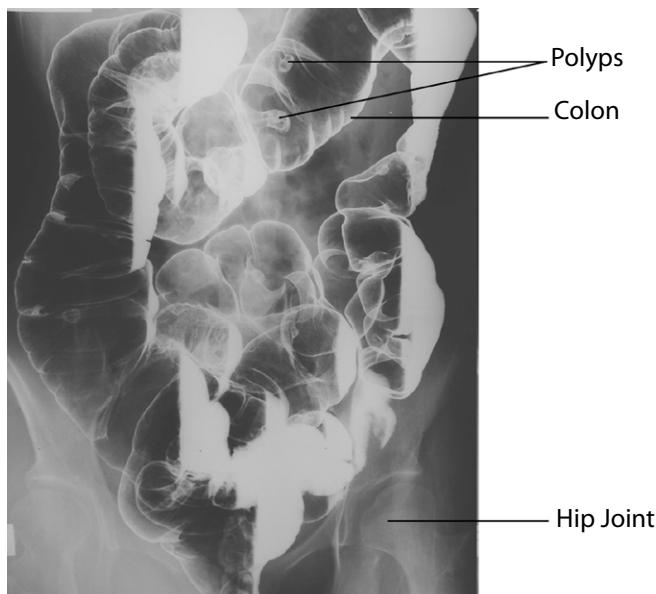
X-ray showing the large intestines after coating the inside of the colon with barium. Two polyps growing on the inside surface can be clearly seen against the silhouette of the colon.
